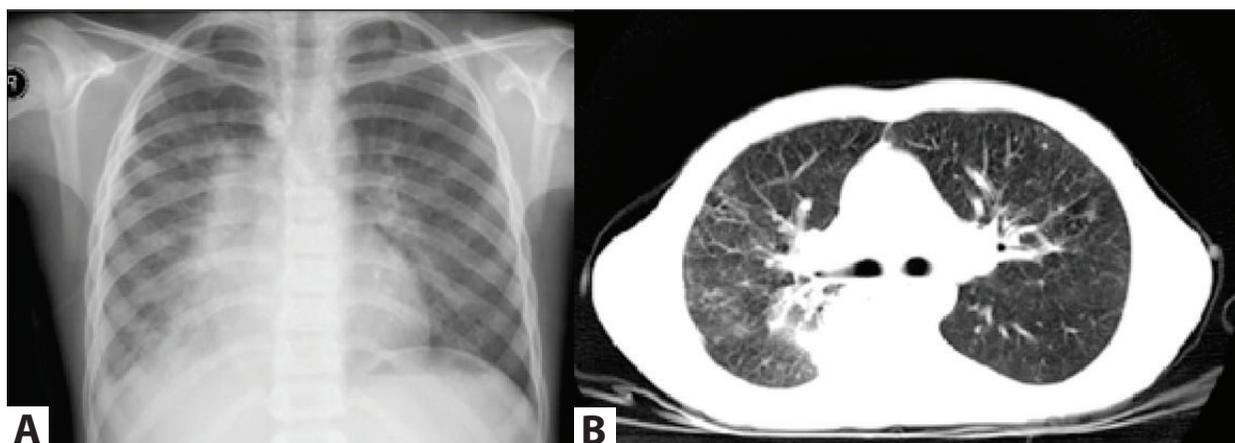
Chest radiography and a thorax CT image, before antifungal treatment.
